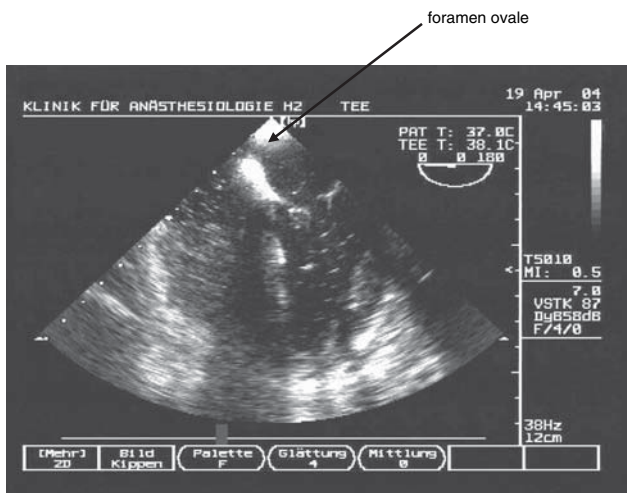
Transoesophageal echocardiogram (bubble study), patent foramen ovale.
